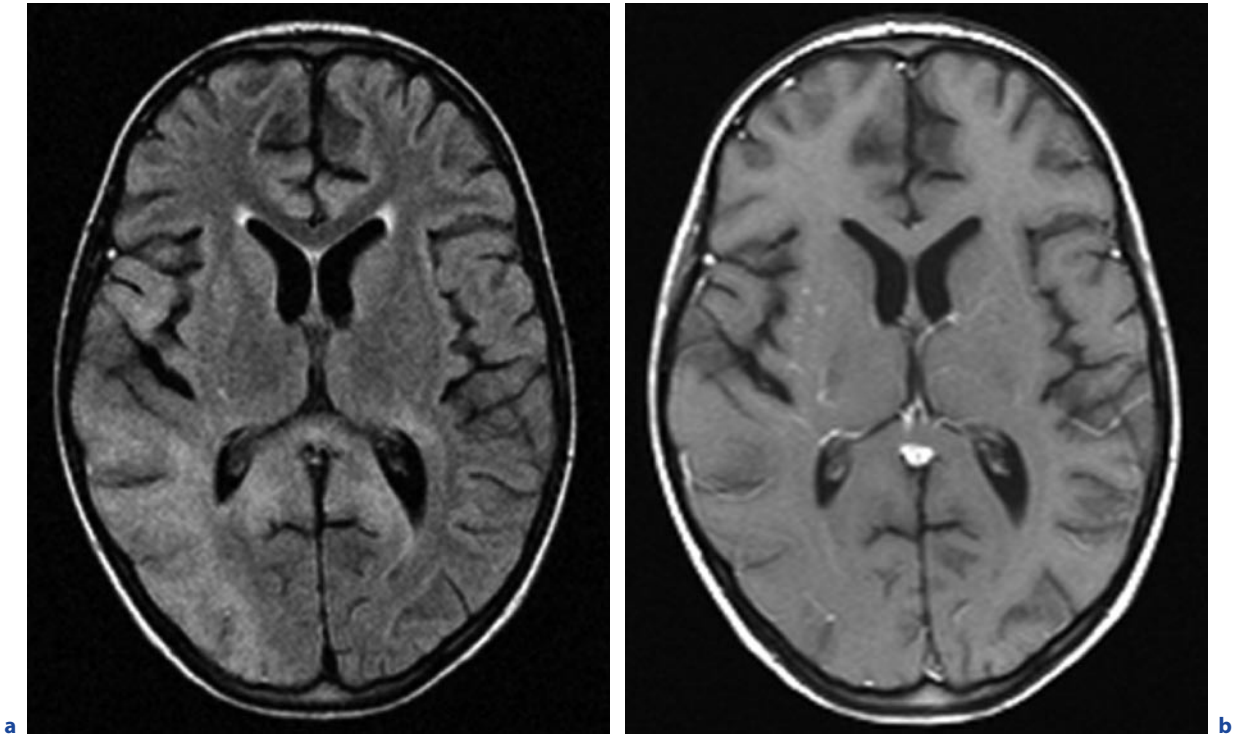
Subacute sclerosing panencephalitis (SSPE) in a 9-year-old girl. a Axial FLAIR image. b T1-weighted image after contrast administration. Swelling and signal alterations in the cortical and subcortical regions mainly of the right but also of the left hemisphere
